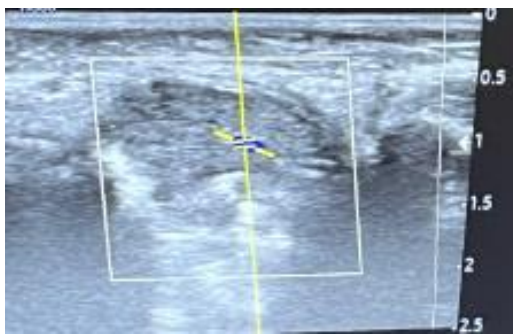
Color Doppler USG
